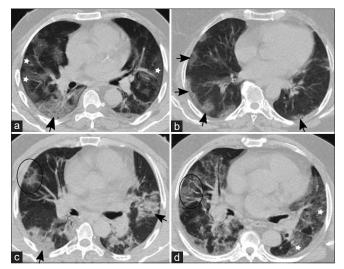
Axial noncontrast chest computed tomography features of radiologically evident coronavirus disease 2019 observed in this study. (a) Bilateral, peripheral patches of ground-glass opacity (stars) with consolidation (short black arrow); (b) Multiple round patches of ground-glass opacity (short black arrows); (c) Reverse halo sign (circle) with consolidation (short black arrow). (d) ground-glass opacity (stars) with interlobular septal thickening (crazy paving) (circle)
